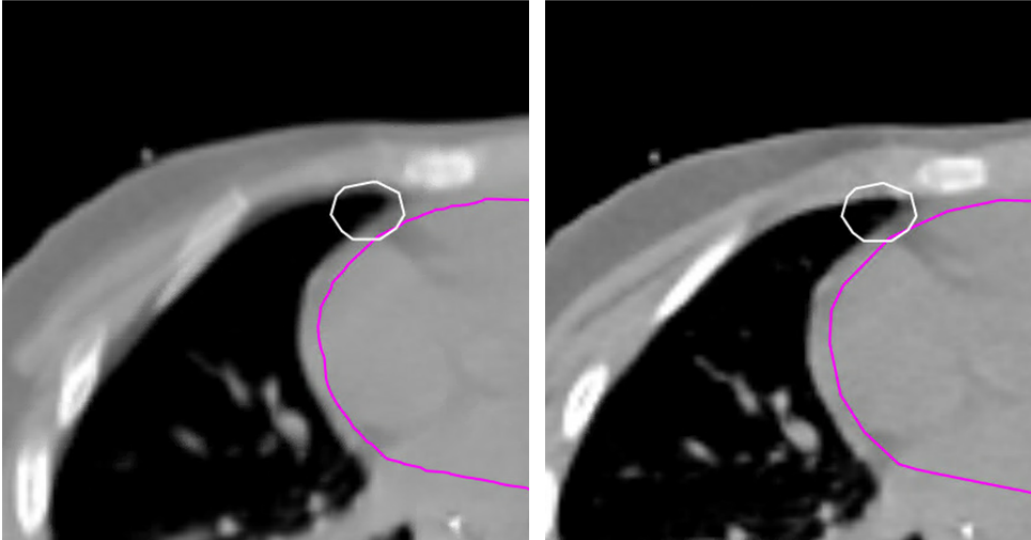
Position of the PTV of metastasis 1 of patient 10 (white) in relation to the heart (pink) in the averaged CT (left) and minimum lung expansion phase (right), one can observe the ED differences that result in the overdosage on the minimum phase are present. From the left to the right images there is a decrease of the volume of lung tissue within the PTV, resulting in an increase of ED and a consequent hot spot.
